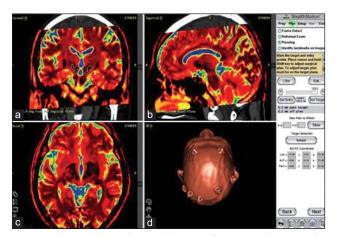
Pre-operation trajectory planning: After computed tomography and magnetic resonance match with image. Merge (a) we reformat images into anterior commissure-posterior commissure plane. (b) The subthalamic nuclei (STN) were shown in white dot line in (a and b) and the substantial Nigra were shown as yellow circle region (yellow dot line in a, and yellow solid line [b] below the STN while the red nuclei were shown at the medial region (blue dot line [a] and red dot line [b]. Then we planned the entry points and trajectory of lead (right side trajectory shown as yellow line and green line shown in the left [b]) after target were set. The trajectory of lead and microelectrode recording were evaluated and the vascular plane was avoided to prevent intraoperative bleeding. (c) The new version of FrameLink displays the angle from the mid sagittal plane and axial plane, which allows surgeons to evaluate the whole tract of the trajectory from entry along the trajectory to the target. After registration, the coordination of fiducial were set by the navigation system (d)
